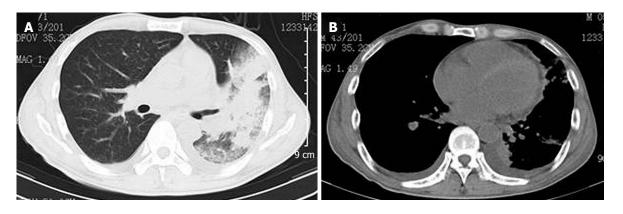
Radiologic findings. Computed tomography showed characteristics of pulmonary infection (A) and hydropericardium (B).
